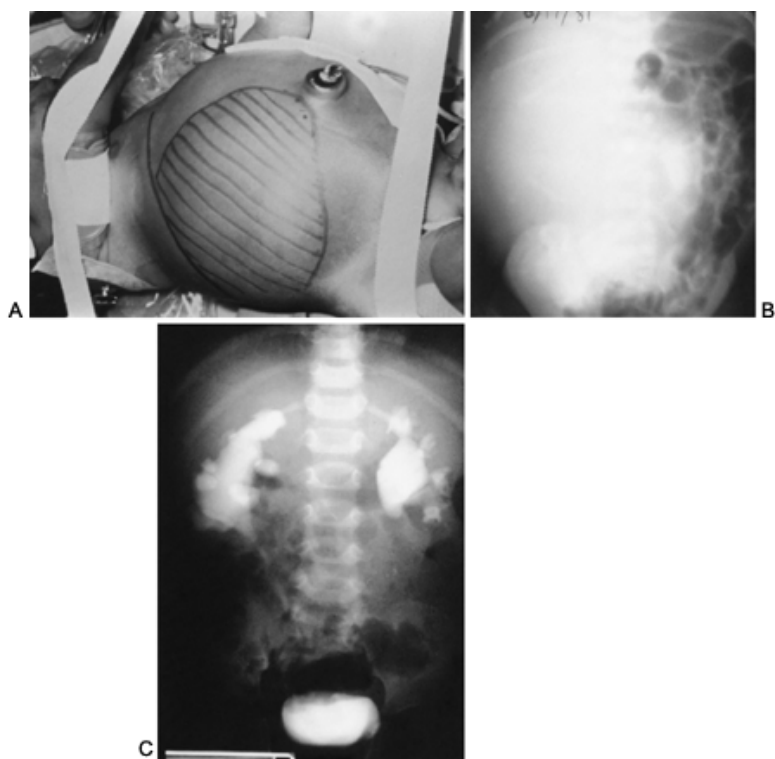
Neonate with large abdominal mass discovered on prenatal ultrasonography and found to have bilateral hydronephrosis. A: Extent of palpable right abdominal mass is marked out. B: Preoperative intravenous pyelogram (IVP) showing large right abdominal mass and left hydronephrosis. The right kidney was found to be severely hydronephrotic secondary to a ureteropelvic junction obstruction, and a right pyeloplasty was performed. A left pyeloplasty was performed subsequently. C: Postoperative IVP demonstrating excellent function bilaterally.
